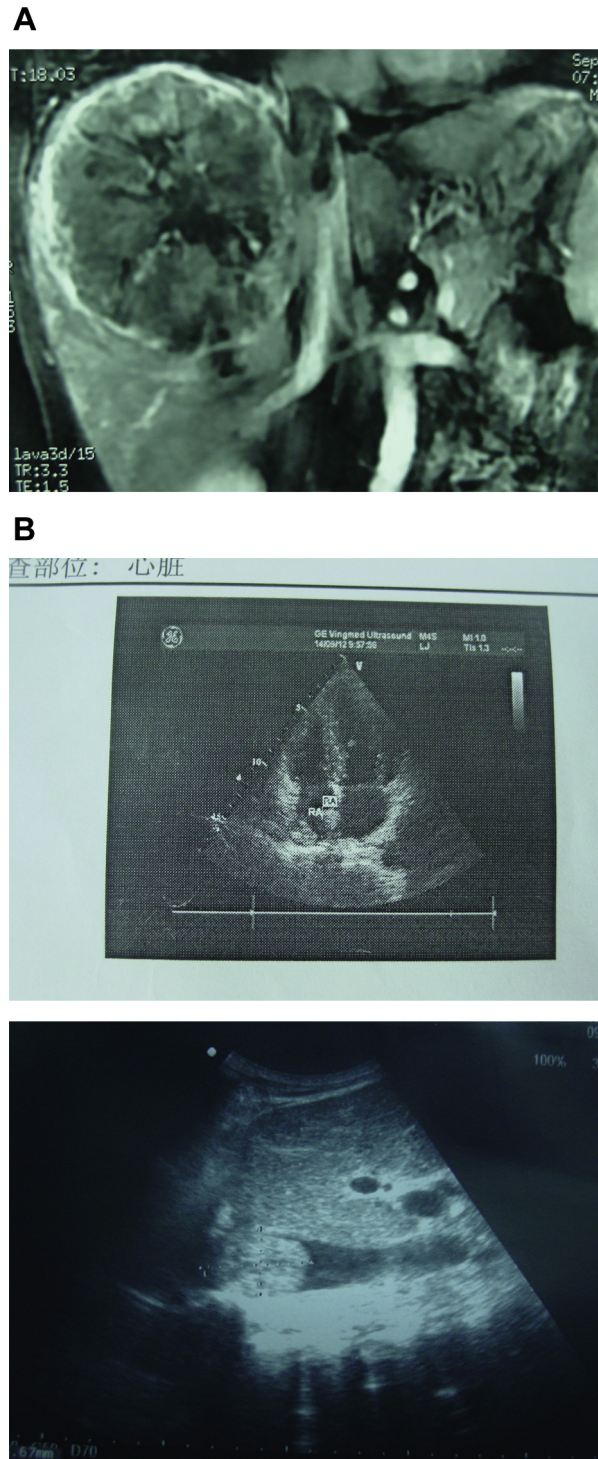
(A) Imaging of HCC with IVC tumor thrombus. Magnetic resonance imaging revealed a 12-cm HCC in the right lobe of the liver with a tumor thrombus advancing into IVC and the RA. (B) Echocardiography scans revealing the tumor thrombus extension into the RA (top) and ultrasound scan revealing the tumor thrombus in the IVC (bottom).
